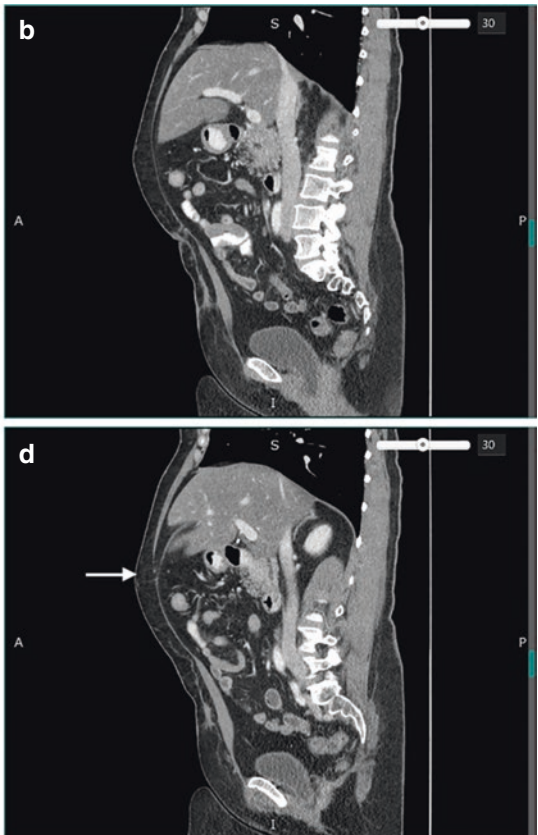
CT images of a patient with both a tiny fat-containing umbilical and epigastric hernia. (a) Axial and (b) sagittal view demonstrating a small fat-containing umbilical hernia. (c) Axial view of the epigastric hernia as
